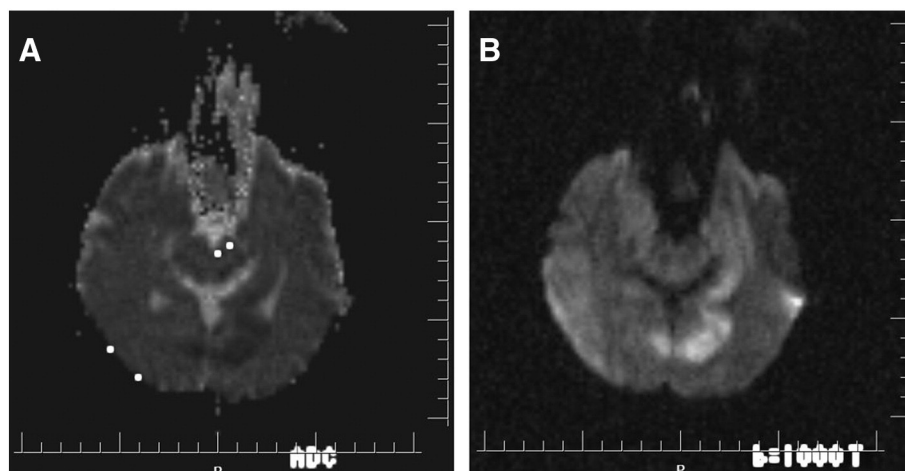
Diffusion-weighted magnetic resonance imaging shows diffusion restriction in cerebello-occipital and left thalamus regions.
